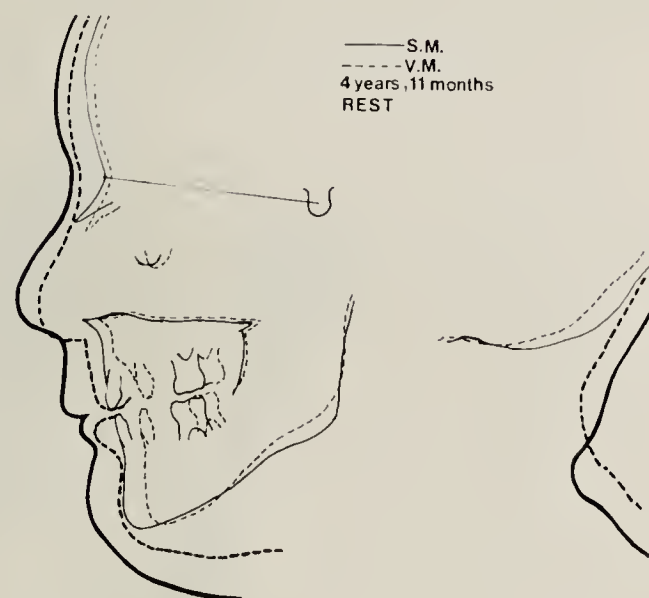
Lateral skull radiographs with mandible in the rest position.
